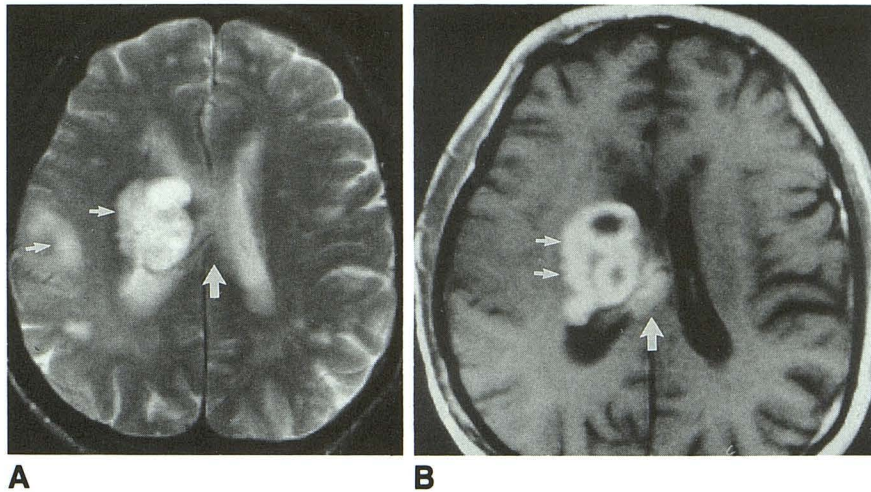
A, Axial T2-weighted image (2500/80/1) shows abnormal signal in the parietal lobe (arrow) and corona radiata (arrow) of the right hemisphere. No signal abnormality is noted in the region of the corpus callosum (large arrow).
